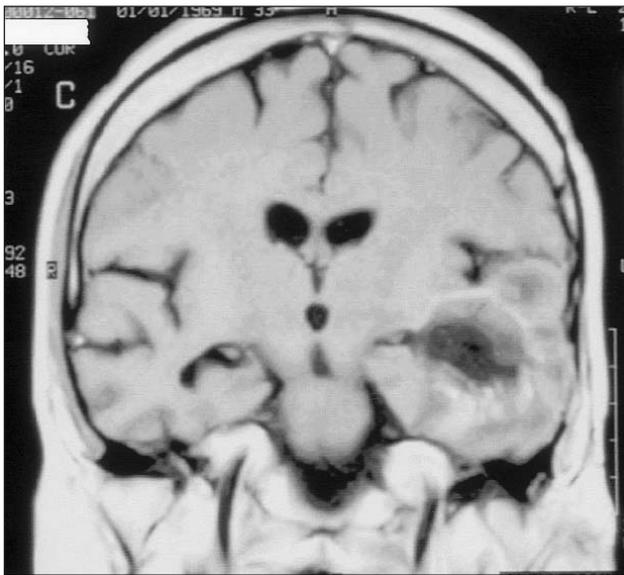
Coronal T1-weighted image shows the tumor in the left temporal lobe
